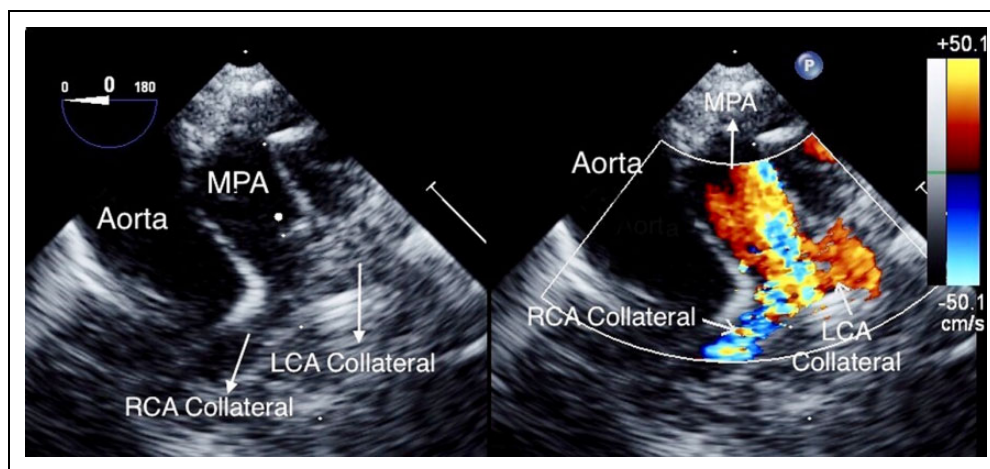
Intraoperative transesophageal echocardiographic image showing the fistulous connections of the right and left coronary arteries to the main pulmonary artery.
